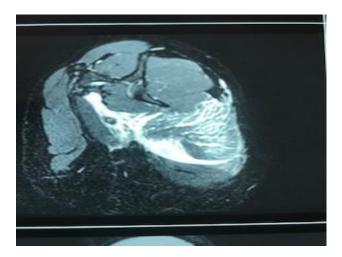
Shoulder MRI scans showing the retracted
